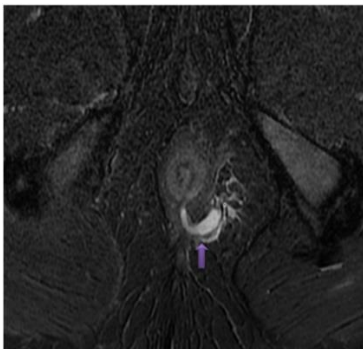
Axial T2 weighted FS MR image showing posterior trans-sphincteric fistula with internal opening at 6 o' clock position - GRADE 3
